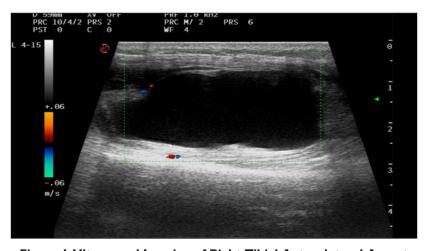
Ultrasound Imaging of Right Tibial Anterolateral Aspect
